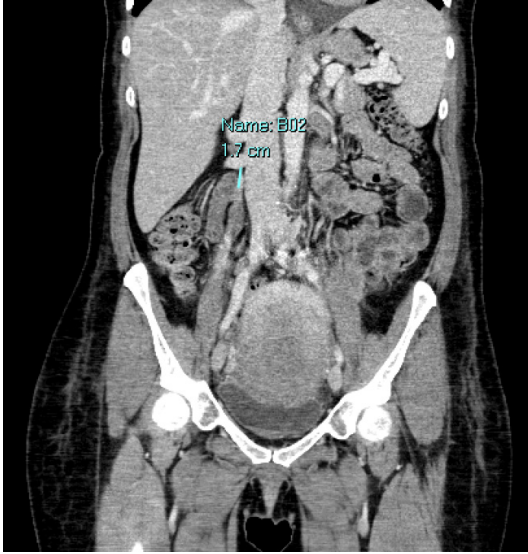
Right ovarian vein thrombosis. CT imaging demonstrating right sided ovarian vein thrombosis.
